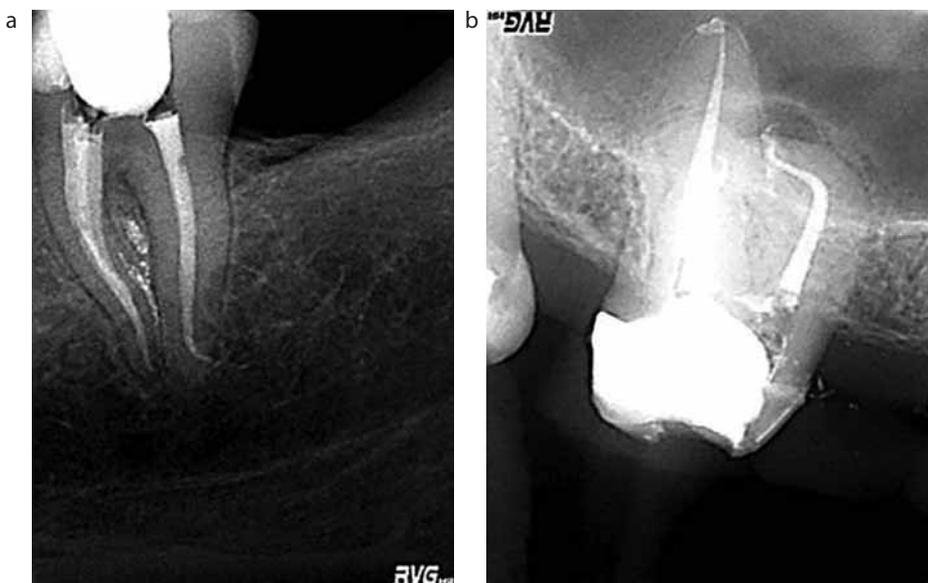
(a, b) The foramen is not always at the centre of the radiographic apex, but may be laterally displaced.
